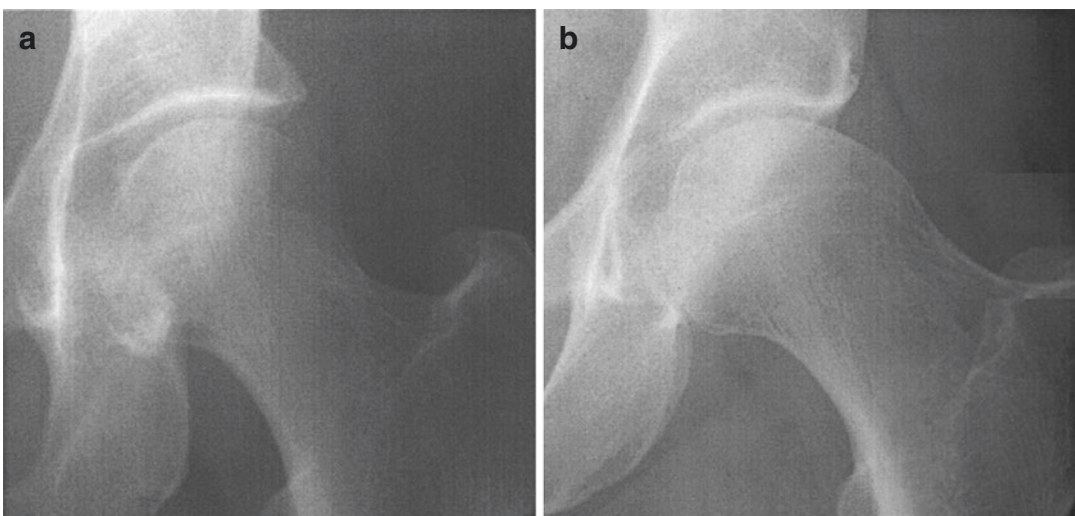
AP radiographs of the left hip, showing normal morphology (a) and a cam type morphology or “pistol grip deformity” (b)
